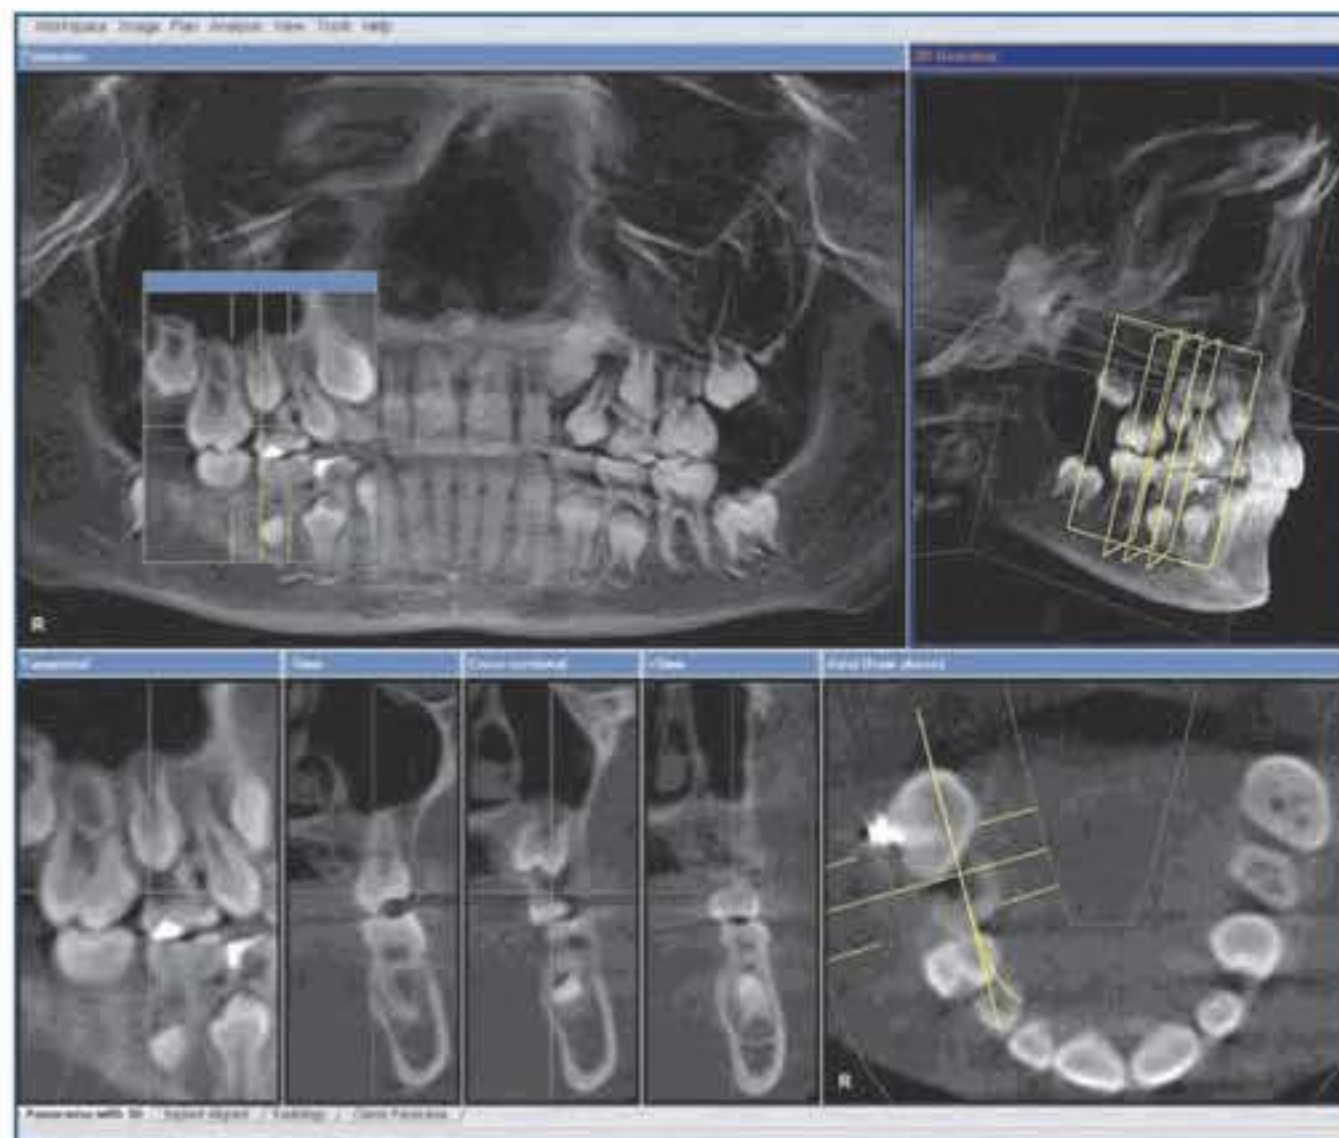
A 10-year-old girl with initial radiological findings. The clinically invisible mesial migration of tooth 16 identifiable in the axial radiographic view arises from the undermining resorption of tooth 55 by the erupted tooth 16, with prospective crowding in the right maxillary buccal segment.
